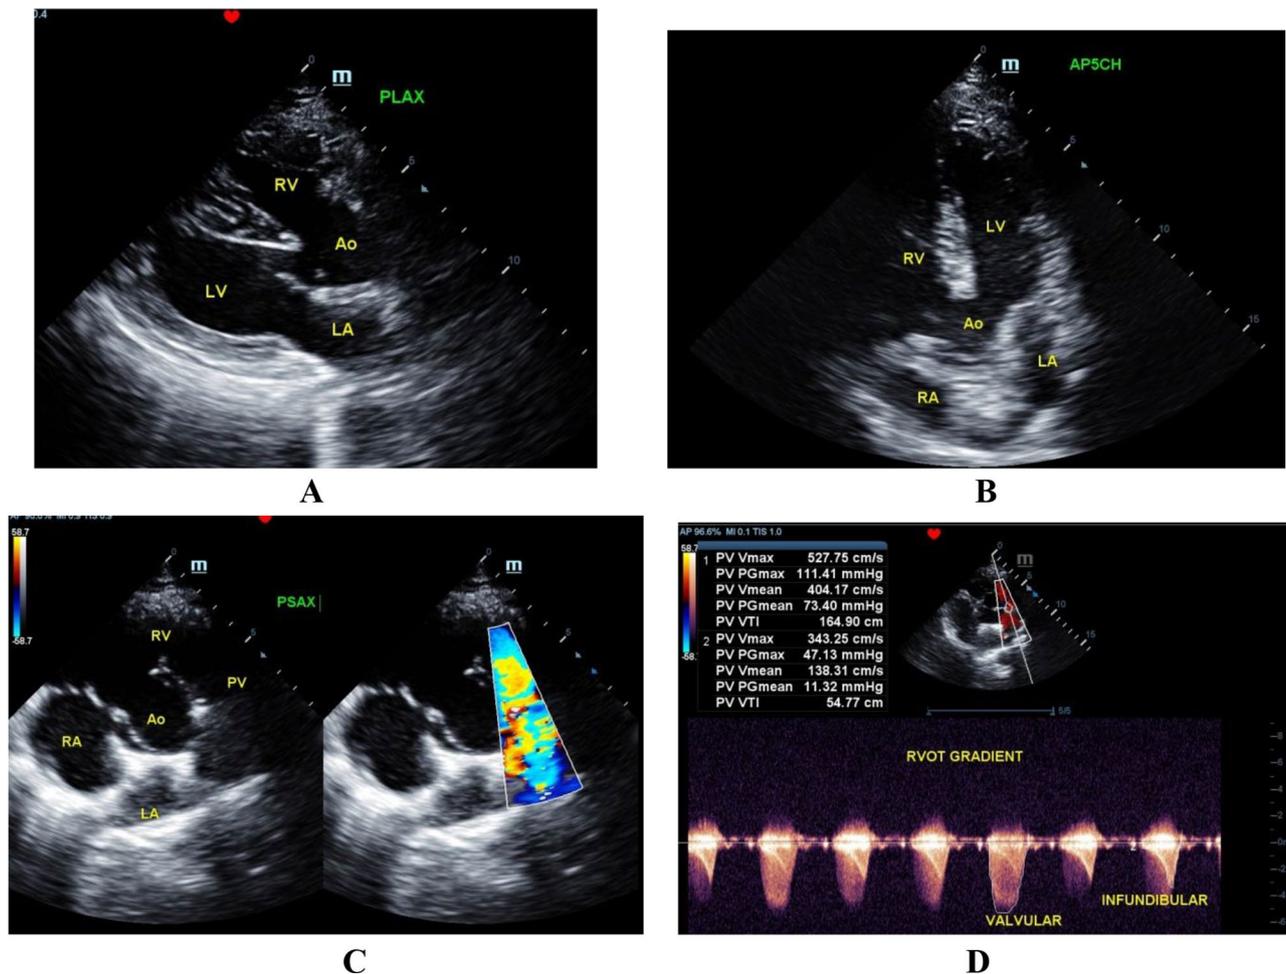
Echocardiographic diagnosis of TOF. A) Parasternal long axis view showed VSD with aortic overriding, B) Apical 5 chamber view also showed the same features, C) Parasternal short axis view showed RVOT stenosis, D) Continuous wave Doppler recording of the RVOT gradient both at valvular and infundibular level
